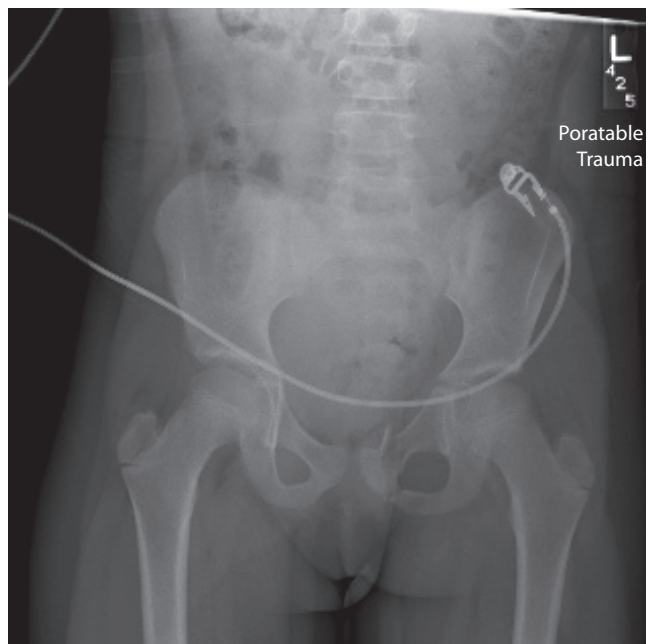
X-ray of an 8-year-old girl with left superior and inferior pubic rami fractures sustained in a motor vehicle collision.
